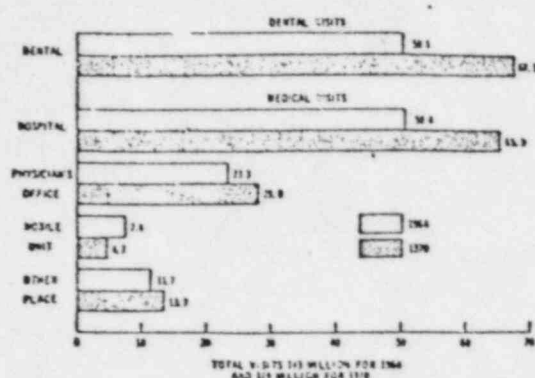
Estimated annual number of x-ray visits in millions in the United States, 1964 and 1970. (Preliminary estimates from the USPHS 1970 x-ray exposure study.) Total visits 143 million for 1964; 175 million for 1970.
